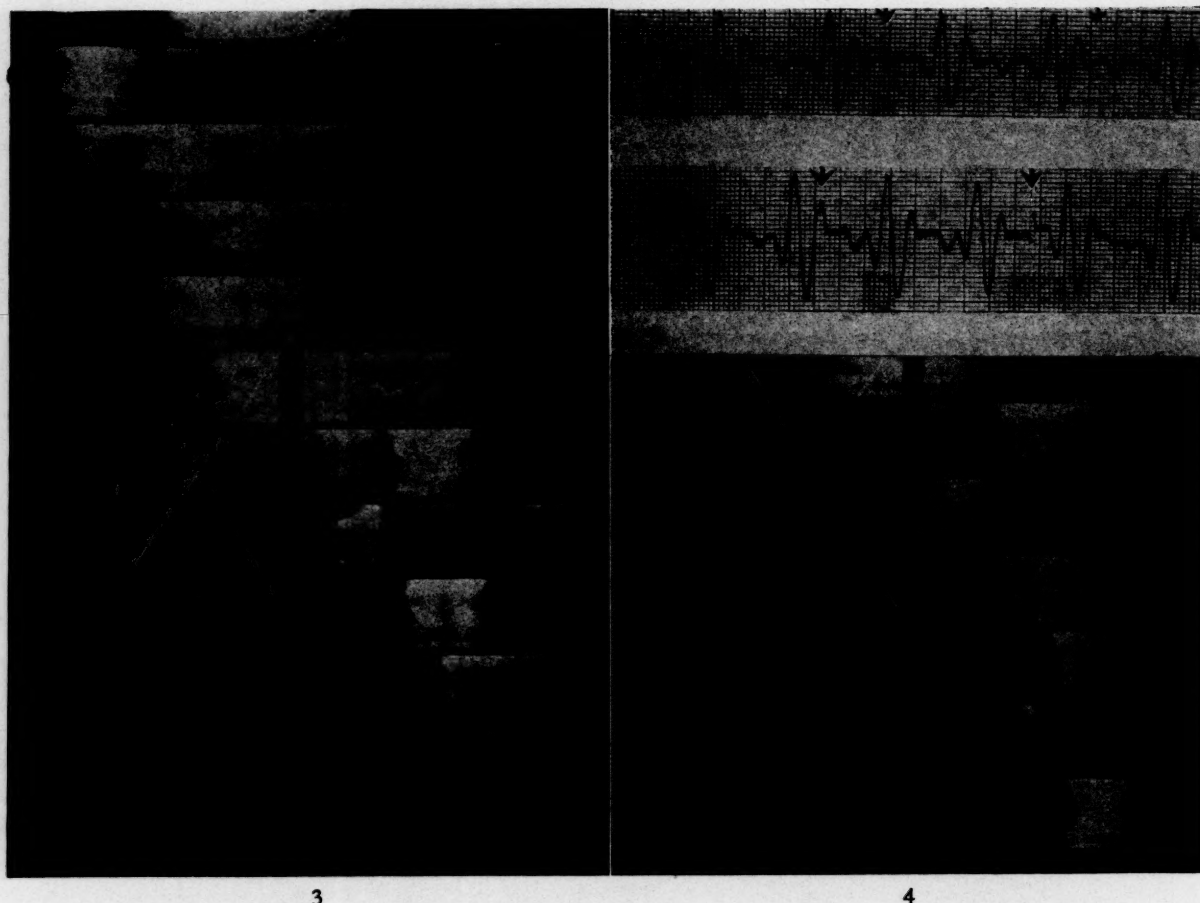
The slit kymogram of the left hemithorax of subject Kp, recumbent, before nitroglycerine. White lines are drawn along shadows of the lead cross taped to the chest to center the film. The left border extends 4.9 cm. to the left of this center. The estimated heart volume was 845 cc., stroke 53 cc. The ballistocardiogram is recorded for six seconds, x-ray exposure occurring three to four and a half seconds from the start, as shown by sharp deflection of the base line below the white dots.
